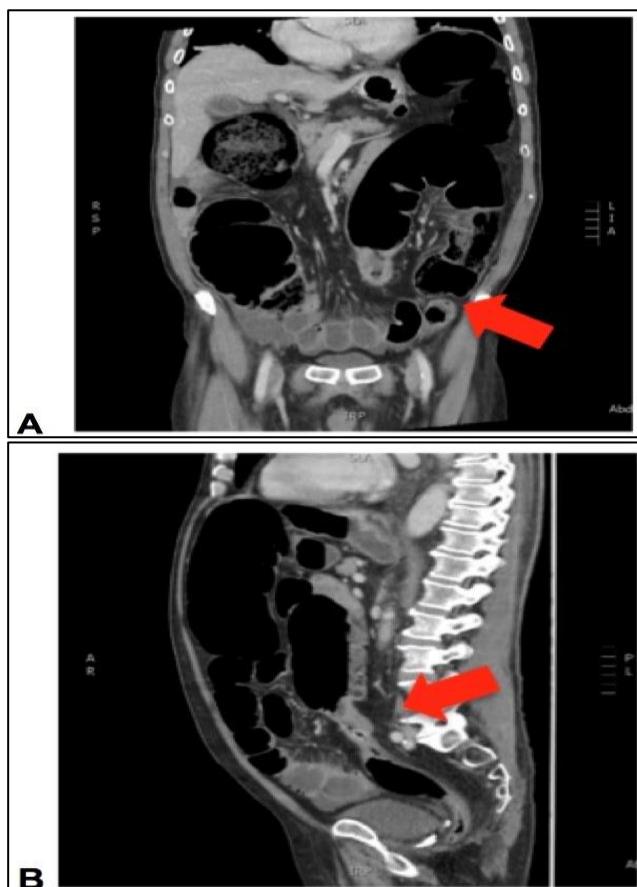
(A and B): Portal venous contrast enhanced CT abdomen and pelvis in the coronal plane and sagittal planes: Large bowel obstruction with a transition point in the mid sigmoid secondary to stenosing lesion and sigmoid colon thickening measuring 4.4 cm.
